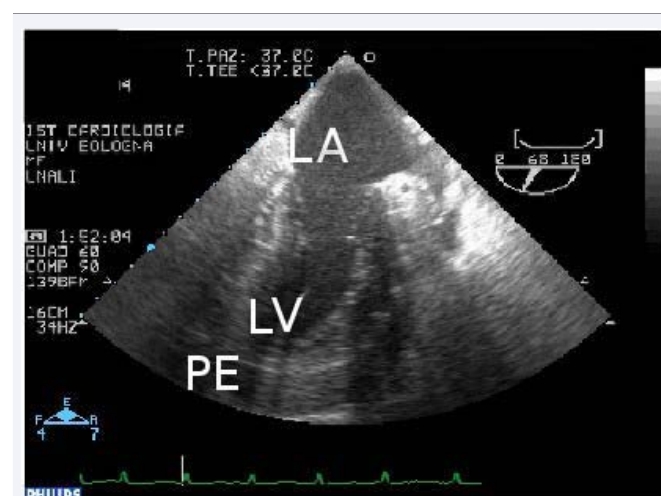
Echocardiographic image of a cardiac tamponade in mid-esophageal long axis view. LA left atrium, LV ventricle, PE pericardial effusion.
